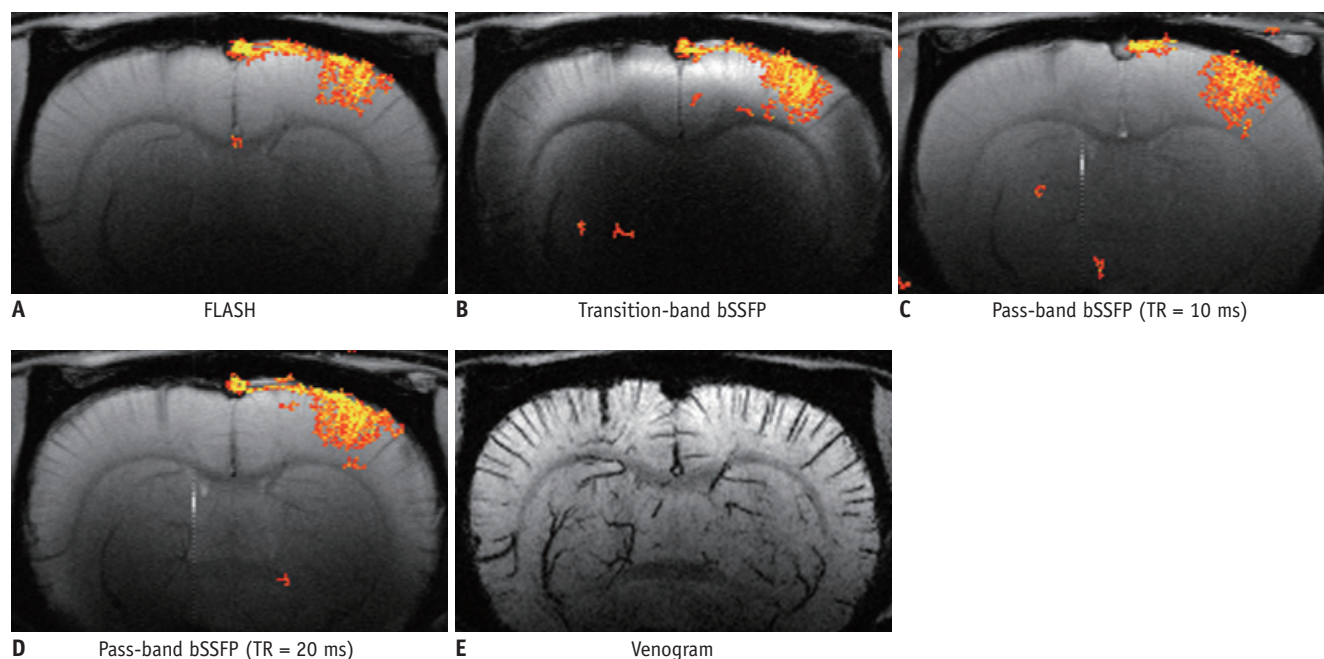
Investigation of activation foci of high-resolution functional MRI maps.
